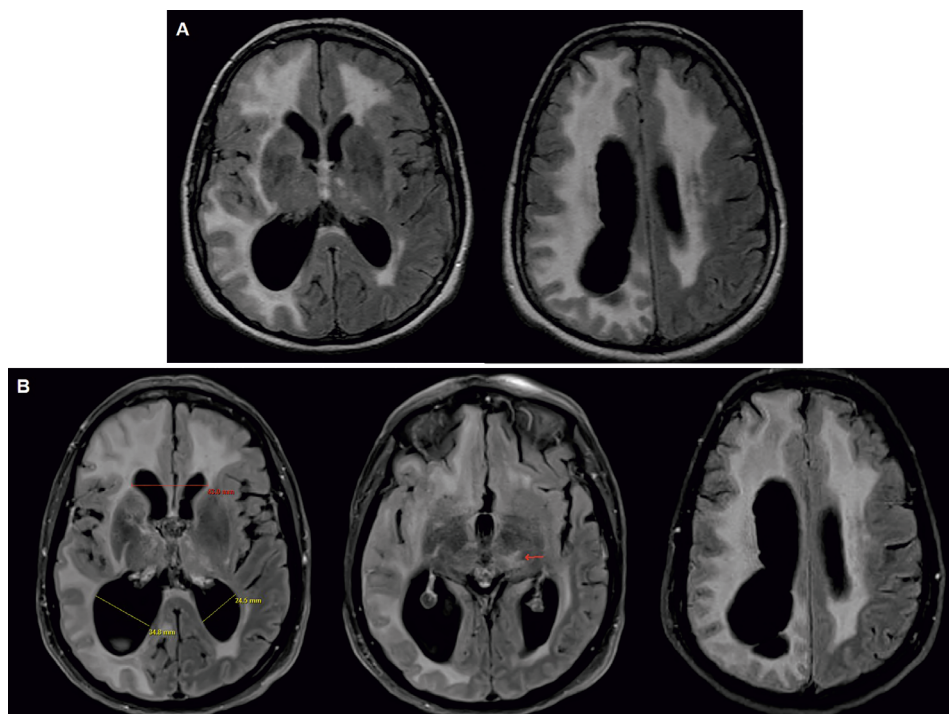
Case 2: T2 FLAIR MRI of the brain. A. Imaging from 2006 demonstrates large areas of confluent hyperintensities involving the white matter of the bilateral cerebral hemispheres, right > left. Associated volume loss is greater on the right, with moderate enlargement of the right lateral ventricle, particularly posteriorly. B. Imaging from 2014 demonstrates stable volume loss (bifrontal ventricular horns [Evan's index] 43.0 mm; right posterior lateral ventricle 34.8 mm; left posterior lateral ventricle 24.5 mm) and confluent cerebral white matter disease, right > left, with thalamic hyperintensities (red arrow)
